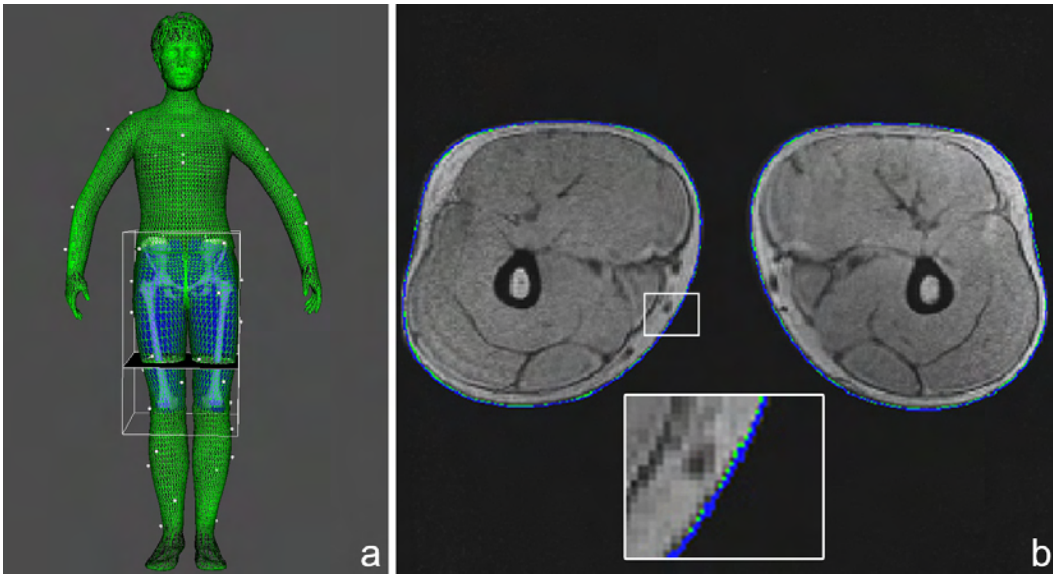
a) Registration result b) The surface contours drawn in a MRI slice: the green (body scan model) and blue (MRI skin model) contours are perfectly aligned.
